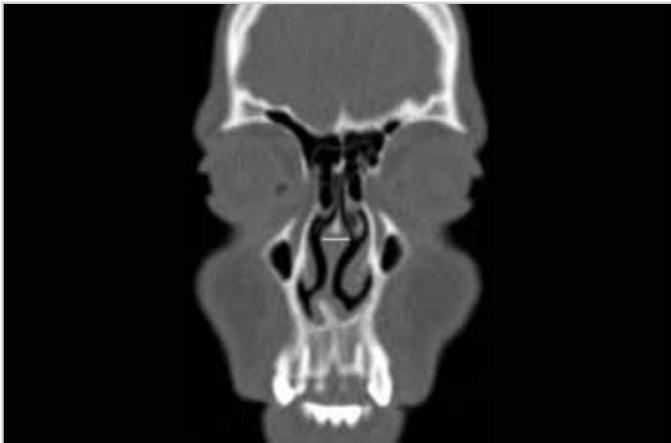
Computed tomography image of nasal septal concha
